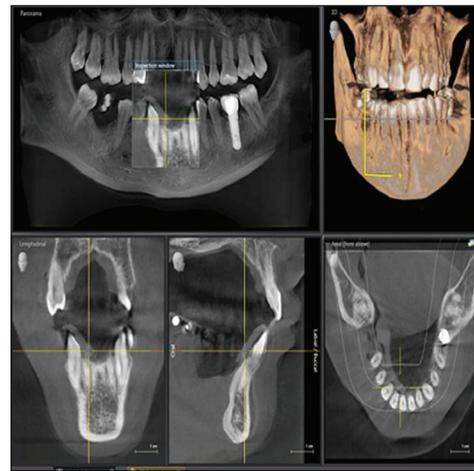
Targeted display and editing of a three dimensional (3D) data volume and its cross sectional views visualized by the cone beam computed tomography software (CS-3D)
